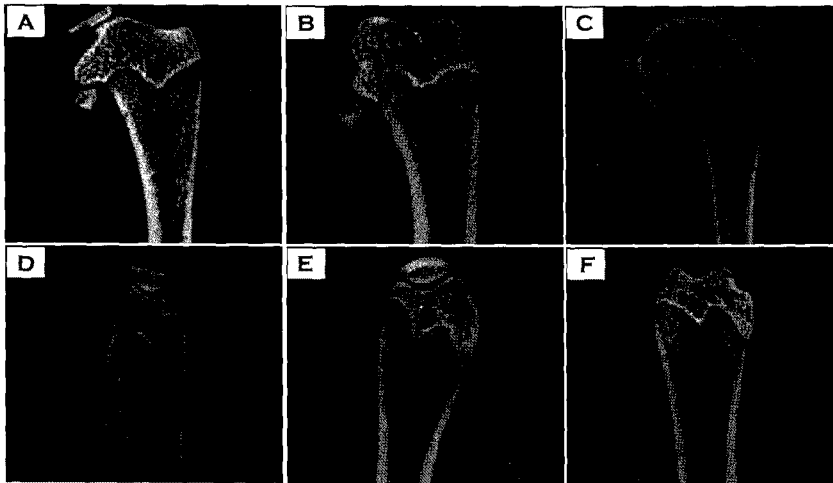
Micro-focus CT images of distal portion of femurs. Femurs were removed after 14 weeks of oral treatment with Aquamin F and/or LAB from 1 month after ovariectomy. (A) sham operation, (B) sham operation and Ca-D diet, (C) ovariectomized and Ca-D diet control, (D) ovariectomized and treated with lactic acid bacteria (1×10^7 CFU/kg B.W., respectively), (E) ovariectomized and treated with Aquamin F 50 mg/kg BW, (F) ovariectomized and treated with lactic acid bacteria (1×10^7 CFU/kg B.W., respectively) and Aquamin F 50 mg/kg BW treatment.
